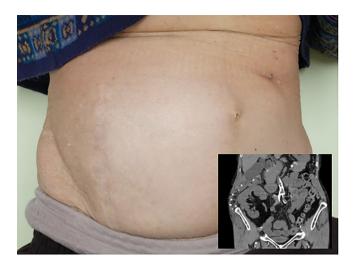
Photograph of the patient from the right side in the standing position after surgery shows that the hernia has been lifted and repaired. Postoperative abdominal computed tomography confirmed the repair
